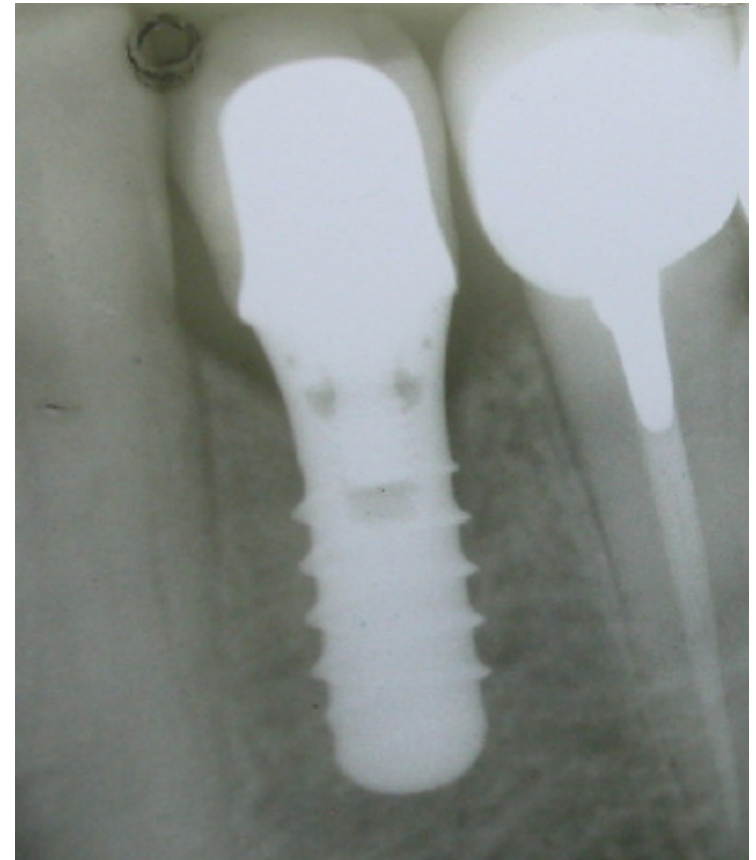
shows the amount of bone expansion achieved and good esthetic results obtained with the prosthesis was achieved in place (Figure 14). Periapical X-ray had been taken after implant placement, and one-year of implant's functional loading which showed the amount of bone resorption one-year of implant's functional loading (Figure 15) [36].
